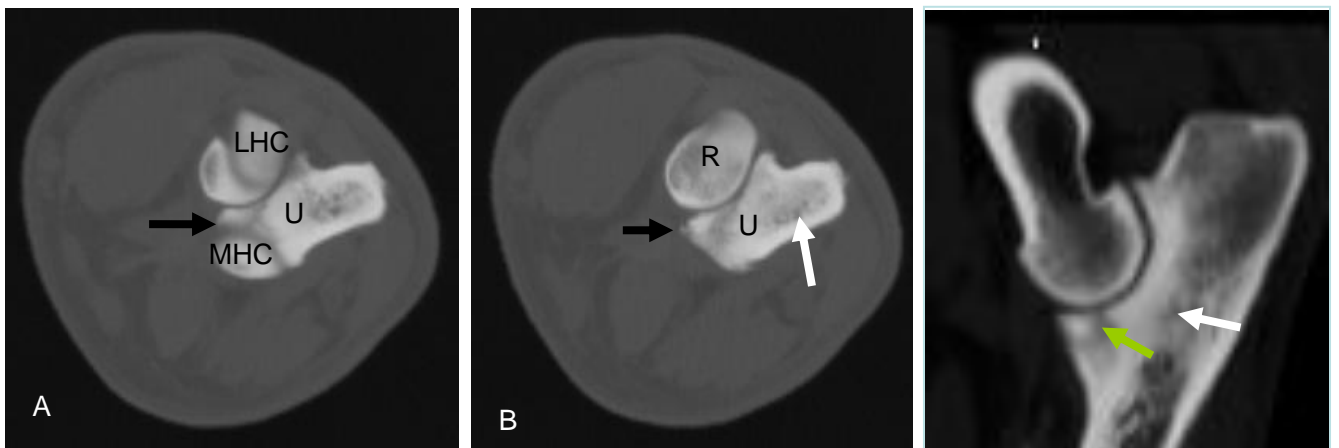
Transverse CT images in the coronoid area (A and B) and a sagittal reconstruction of the ulna (C) of the right elbow. The lateral humeral condyle (LHC), the medial humeral condyle (MHC), the ulna (U) and the radius (R) can be easily recognised. A radiolucent line is visible on the sagittal reconstruction in the area of the medial coronoid process (green line) representing a large fragment (9 x 5 mm) (black arrows). Extensive sclerosis can be noticed in the ulna (white arrows).
